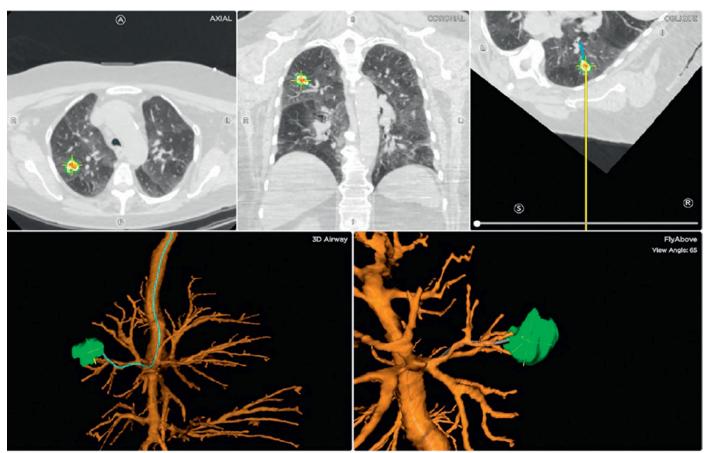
Electromagnetic Navigation Monitor. Location of the pulmonary lesion is displayed in three different axes of computed tomography imaging.
